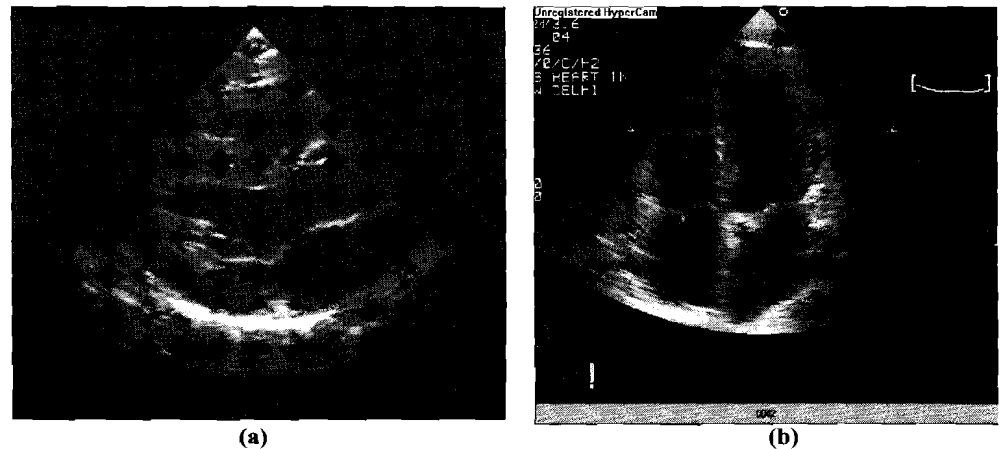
Two-dimensional echocardiographic images showing (a) PLAX view (b) Four chamber view
